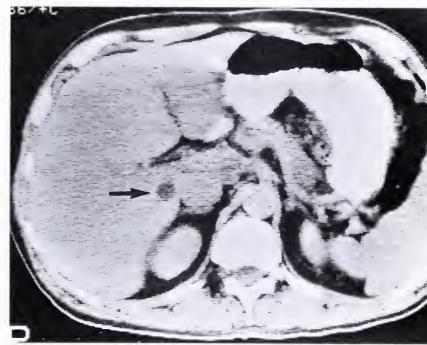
Axial CT section through liver shows cyst (arrow) in right lobe lateral to IVC.
